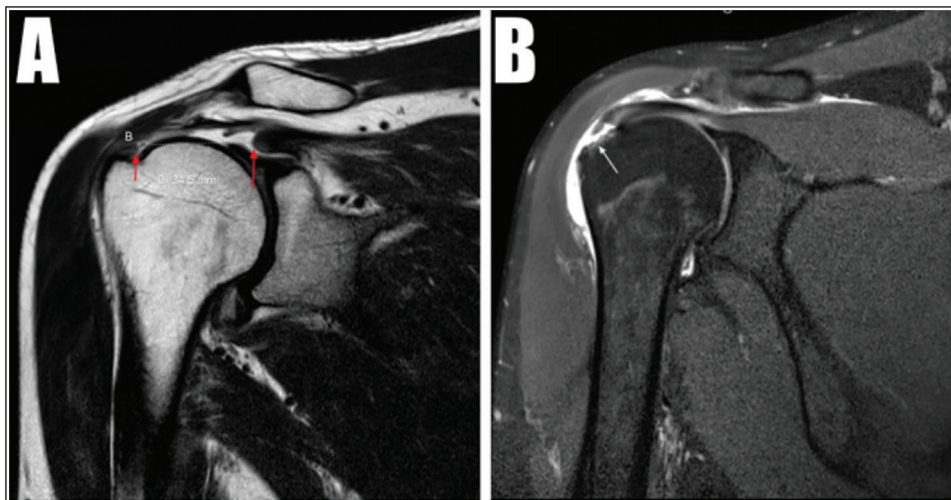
Full-thickness tear of the supraspinatus tendon (SST) in two different subjects: (A) T2W coronal shoulder MRI showing wide discontinuity of the SST with a fluid-filled gap (3.5 cm) between the torn ends (red arrows), and (B) proton density-weighted fat-saturated coronal section revealing a complete discontinuity of the SST at its insertion site (white arrow) into the irregular greater tuberosity (the tendon gap is filled with fluid which is continuous with the subdeltoid bursa)
